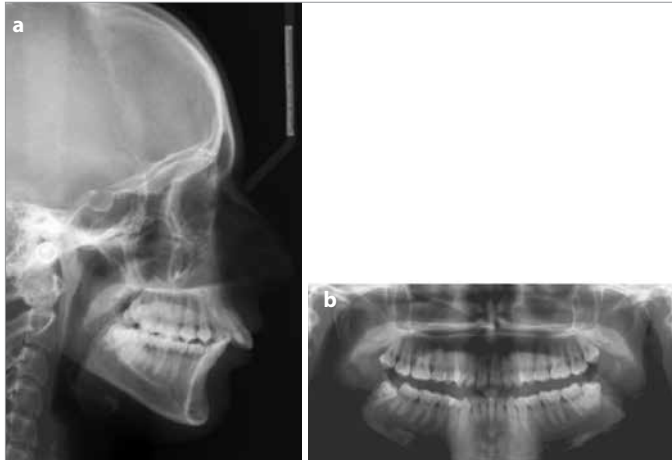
a, b. Pretreatment lateral cephalometric (a); panoramic radiographs (b)
